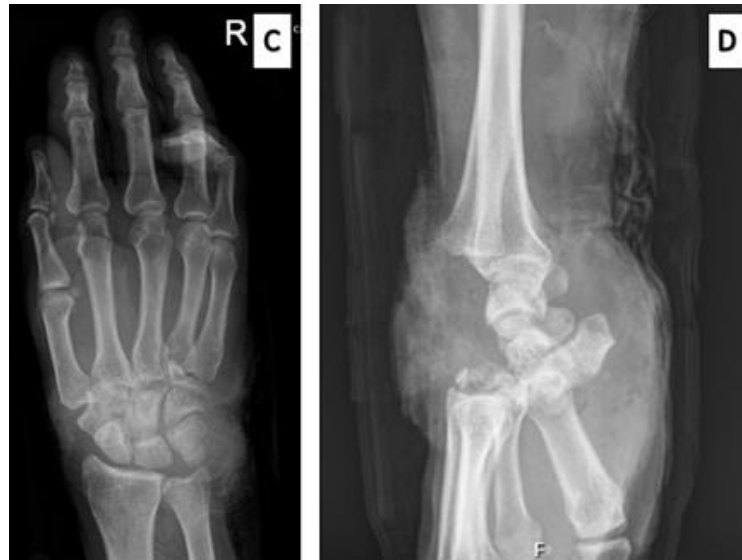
(C) In the posterior-anterior (PA) radiograph of the right wrist, fractures in the 2nd row of the wrist bones of the right hand are apparent. (D) The lateral (LL) projection showcases a complete dislocation of the II-V metacarpal bone in the dorsal direction with fragments of the metacarpal bones, along with subluxation of the I metacarpal bone dorsally.
